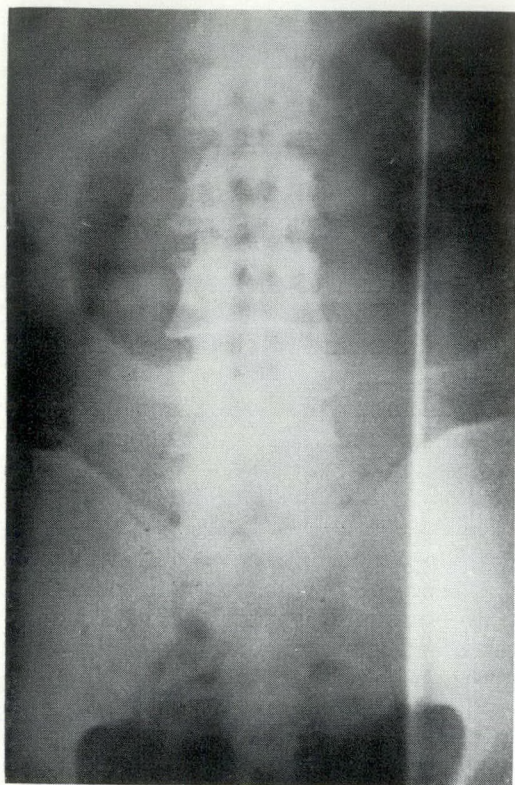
Plain film taken with the patient in the supine position.
